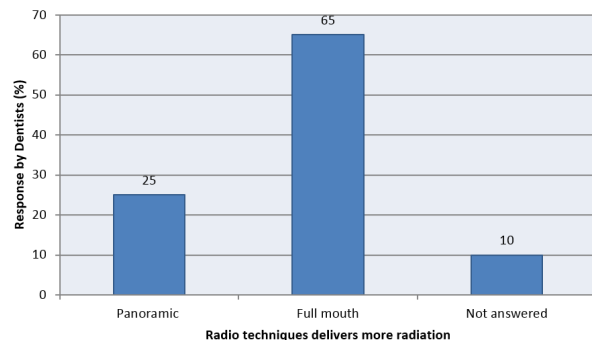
Showing that the majority of full mouth periapical radiography delivering more radiation than panoramic.
